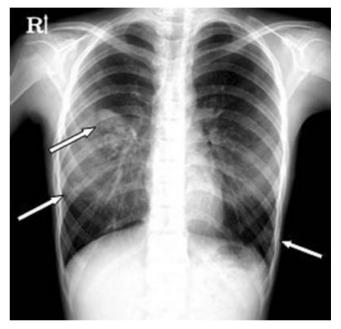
The chest radiography shows pulmonary arteriovenous malformations (arrows) in the middle and lower lobe of the right lung and lower lobe of the left lung.
